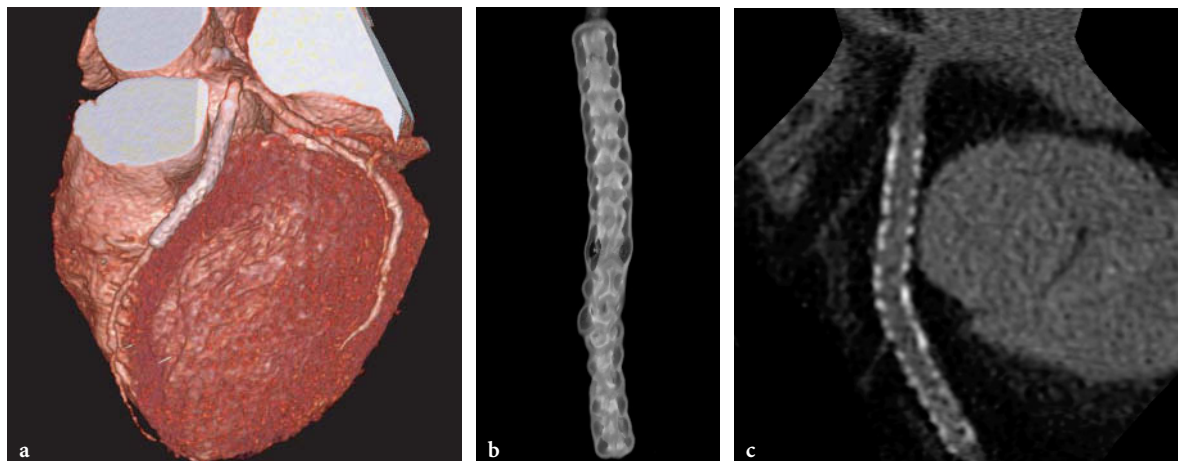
Coronary CT angiography examination using a 64-slice CT scanner with 0.6-mm collimation and 0.33-s rotation time in a patient with a long stent in the left anterior descending coronary artery. The location, extension, and properties of the stent are readily visualized with volume-rendering technique (VRT) display (a, b) Image reconstruction using a sharp filter kernel and curved MPR display (c) allows for optimal diagnostic visualization of the patent in-stent lumen over the entire course of the stent. (Case courtesy of Toyohashi Heart Center, Japan)
